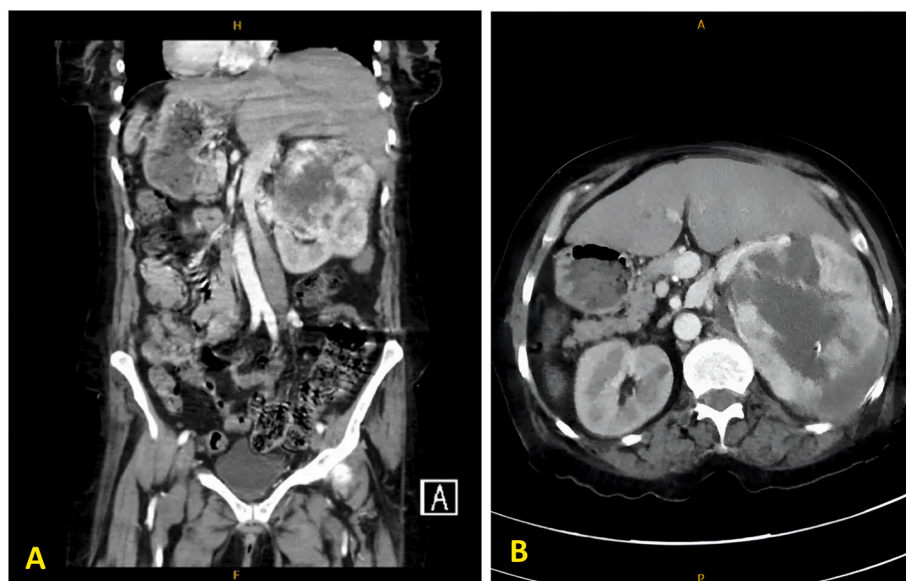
(A–B). Abdominopelvic CT scan, both axial and coronal cuts, demonstrates a left renal mass measuring 10.5 x 10.2 x 12.6 cm. Mirror imaging of intra-abdominal organs which is a finding consistent with SIT.
